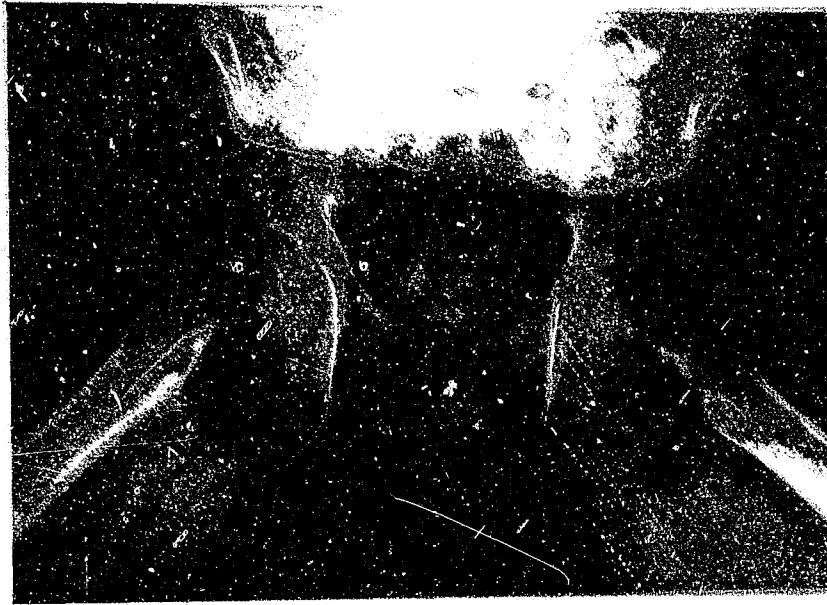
A frog-leg lateral radiograph of the hips showing a Southwick's head-shaft angle. Both hips are involved.
